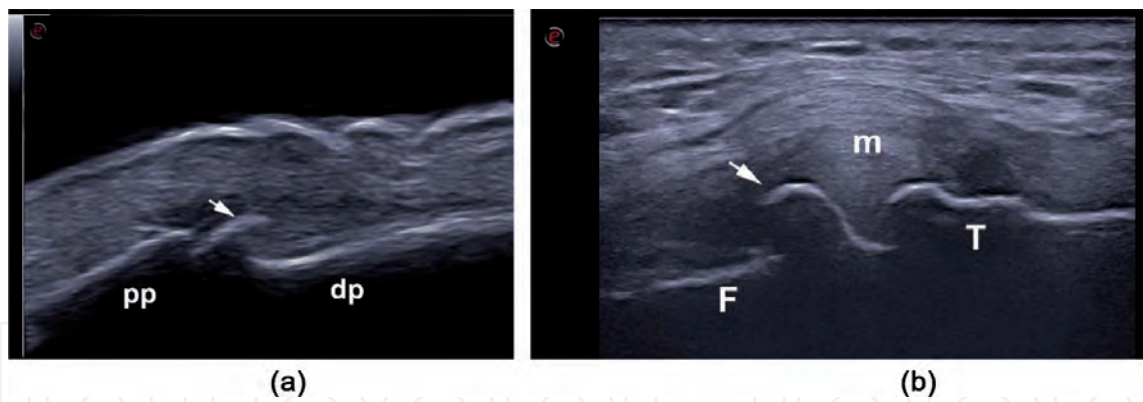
Ultrasound images of step-up bony prominences, at the level of the interphalangeal (a) and femurotibial (b) joints, suggestive for osteophytes. pp – proximal phalanx, dp – distal phalanx, F – femur, T – tibia, m – meniscus, arrow – osteophyte.*
